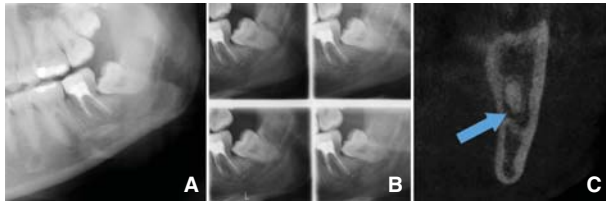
Left mandibular third molar: (A) panoramic image; (B) Stereo-scanogram; (C) CBCT section coronal view. Arrow indicates the mandibular canal.
